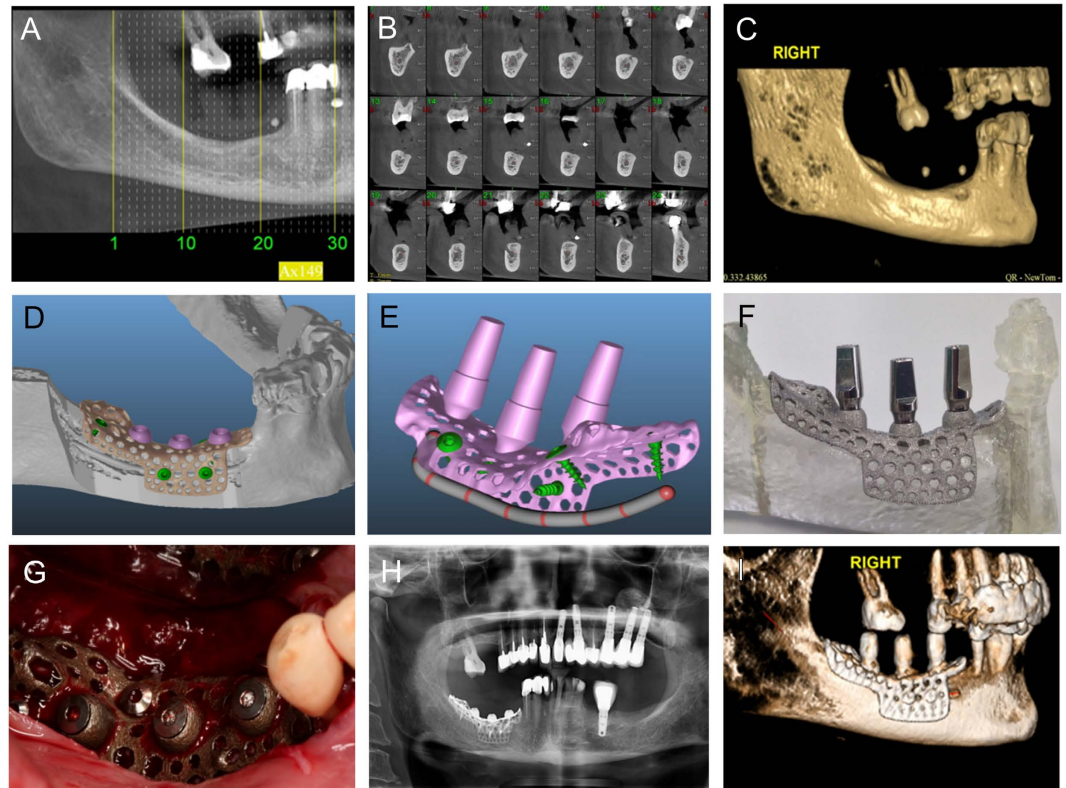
A patient customized endosteal implant was created to enhance bone regeneration for future dental implant placement. A CT scan was taken of the patient (A) to plan implant placement (B, C). A customized Ti-6Al-4 V implant was designed in software (D, E), with purple representing implant posts and green representing stabilizing screws. The implant was manufactured as one piece (F) and implanted in the patient (G). A follow-up panoramic X-ray was taken to evaluate osseointegration and the bone to implant contact after three months (H), and a CT scan performed after eight months (I).
